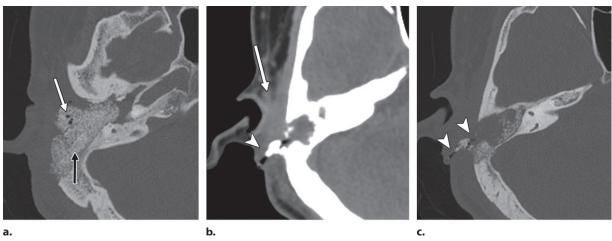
CWD surgical cavity obliteration. (a) Axial bone window CT image shows hydroxyapatite granules obliterating the mastoid bowl (black arrow), with foci of gas (white arrow) permeating the cavity. (b, c) Axial soft-tissue window (b) and bone window (c) CT images show signs of infection of the surgical site: gas in the cavity, fragmentation of the material, and fistulous communication with the skin (arrowheads). There is also thickening and stranding of the soft tissues (arrow in b) adjacent to this process.
